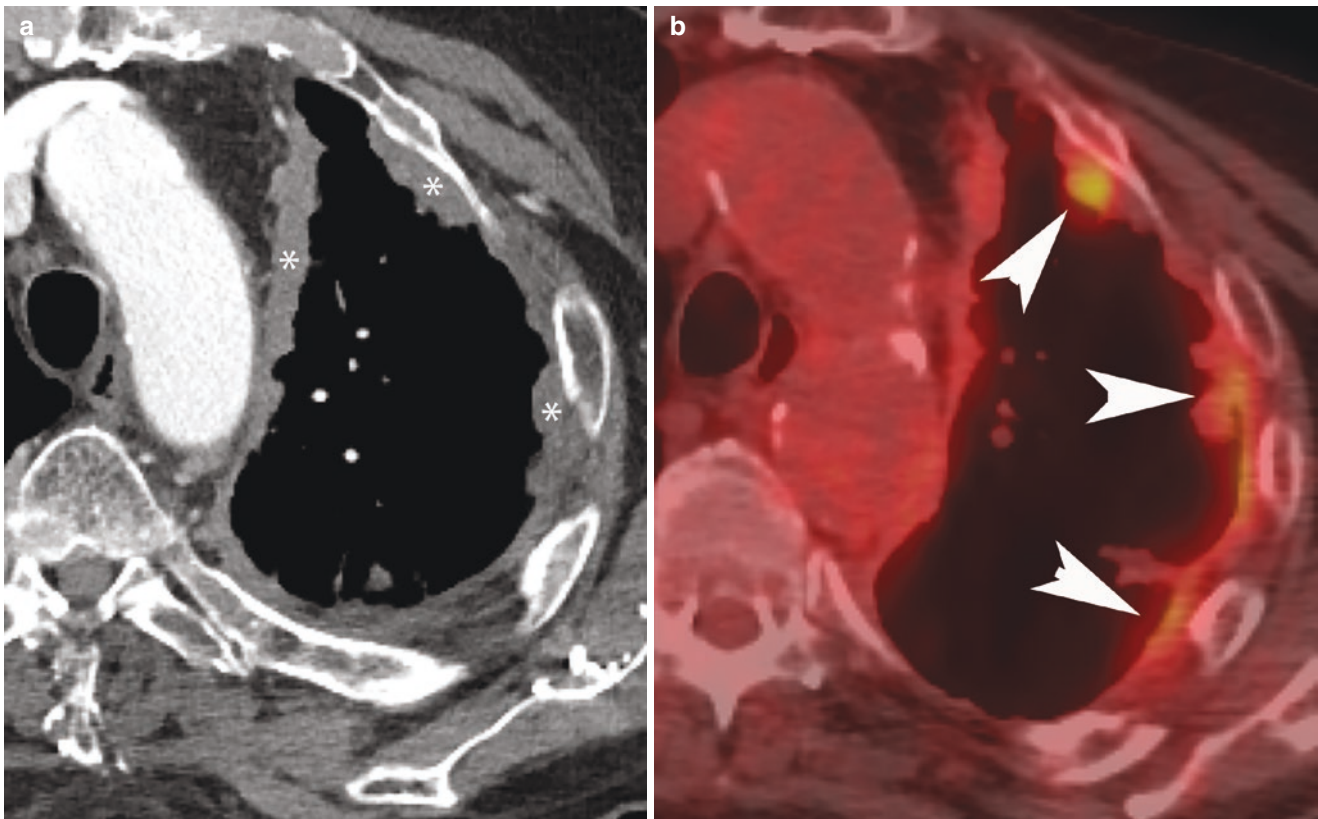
(a) Contrast-enhanced axial CT with left circumferential nodular pleural thickening (*), similar to that seen in mesothelioma. (b) axial FDG PET/CT demonstrates increased FDG uptake in the pleural tumor (arrowheads)
